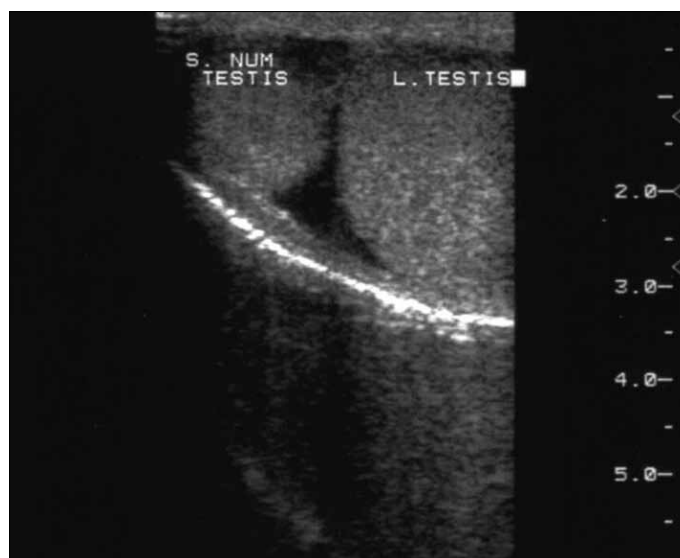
Ultrasonogram showing the supernumerary testicle having the same echogenicity as the normal testes located in the left hemiscrotum
